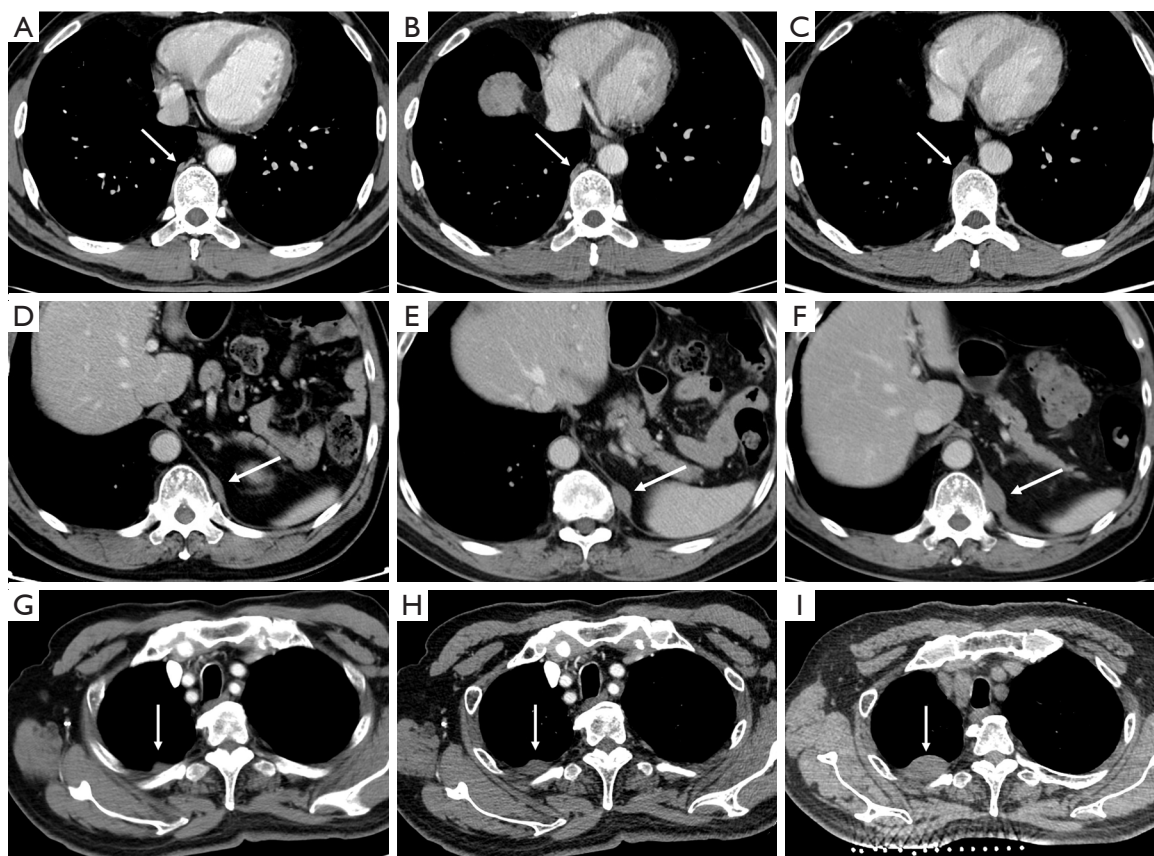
Blind spot on chest CT: pleura. (A-C) A 57-year-old male with lung metastases after right upper lobe adenocarcinoma resection. There was initially missed gradual thickening of the right paravertebral pleura (arrows), which was diagnosed as pleural metastasis. (D-F) A 69-year-old man with a neuroendocrine tumor in the anterior mediastinum. A initially missed spindle-shaped nodular shadow was observed in the left diaphragmatic pleura (arrows). Follow-up chest CT revealed enlargement of this nodule, suggesting a metastatic lesion. (G-I) A 71-year-old male with right lower lobe lung cancer. Enhanced CT revealed missed nodular thickening of the right pleura (arrows). The final biopsy confirmed aggressive fibromatosis. These lesions were all missed in the first two scans. CT, computed tomography.
